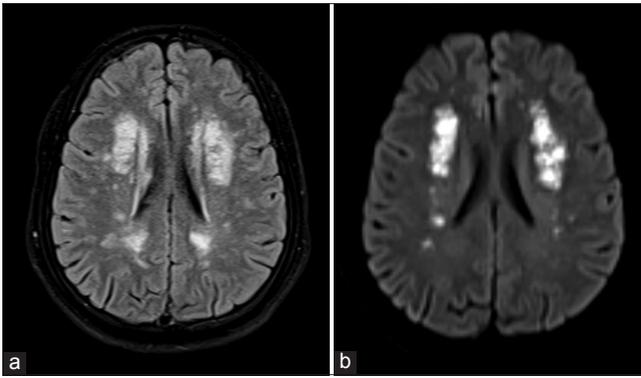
(a) Magnetic resonance imaging brain axial fluid-attenuated inversion recovery image shows extensive periventricular white matter hyperintense signals, (b) magnetic resonance imaging brain axial diffusion weighted imaging image shows acute infarcts in both centrum semiovale regions
